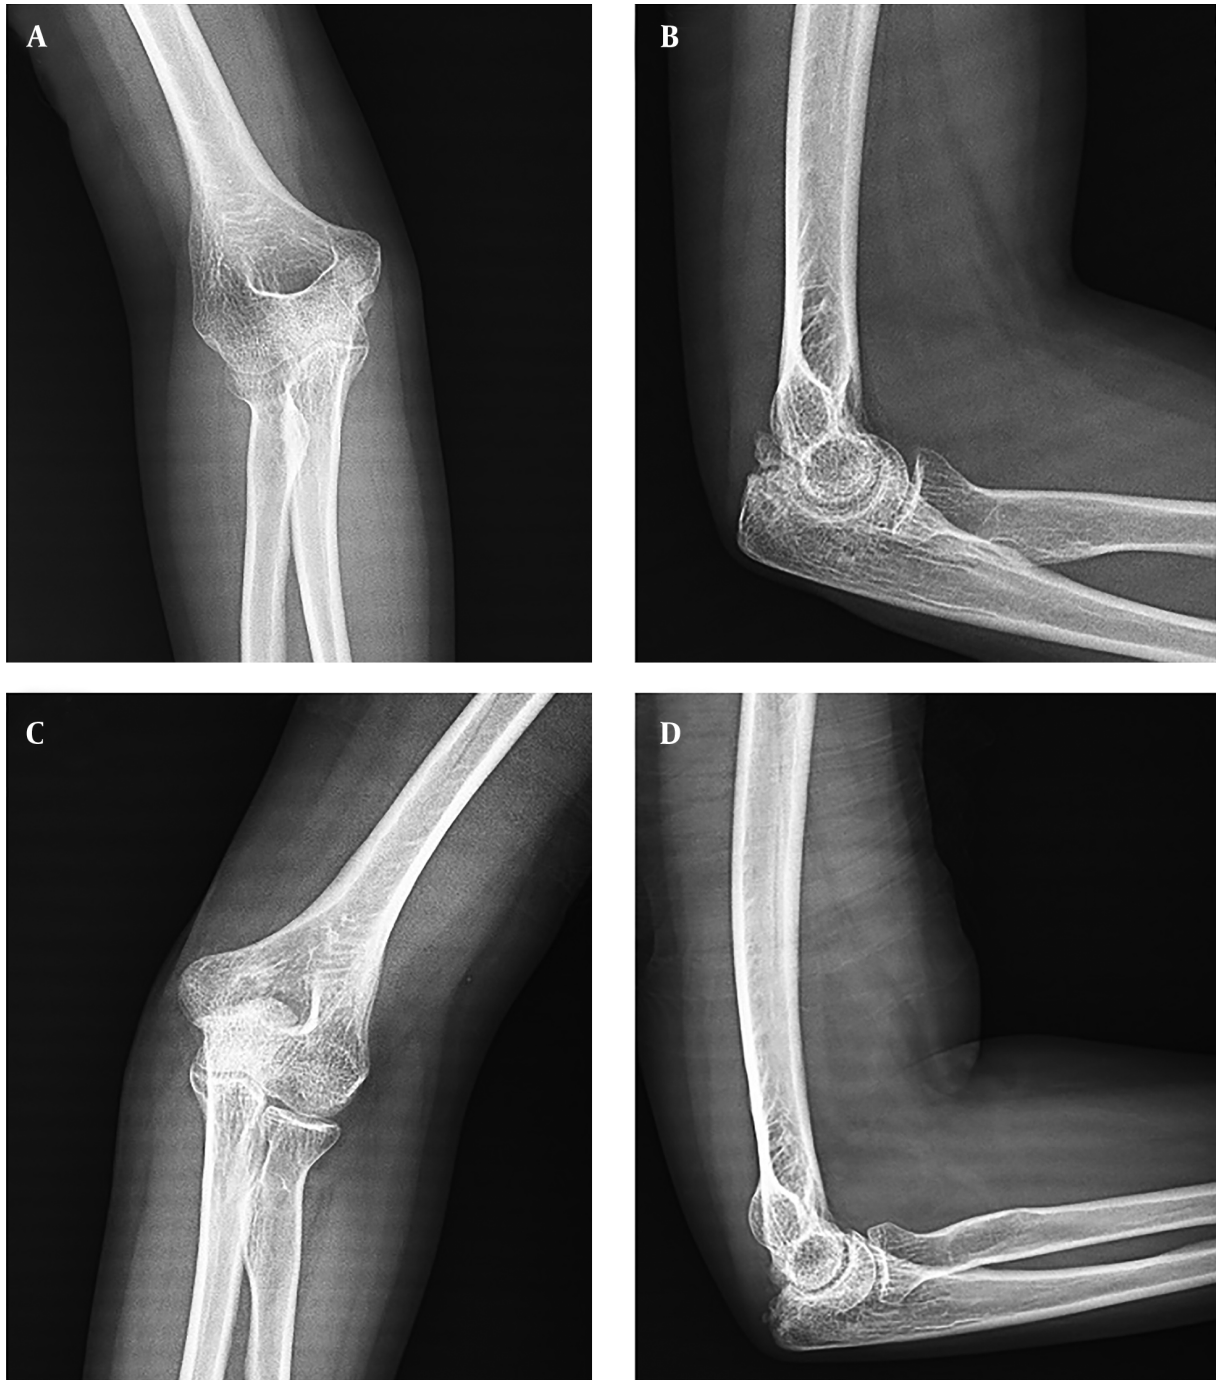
A, anteroposterior and B, lateral pre-operative radiographs of a patient with atraumatic elbow stiffness; C, anteroposterior and D, lateral post-operative radiographs of the same patient
